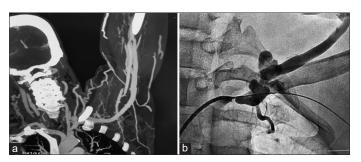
(a) Computed tomography venogram showing near total subclavian vein occlusion; (b) fluroscopy showing subclavian chronic total occlusion
